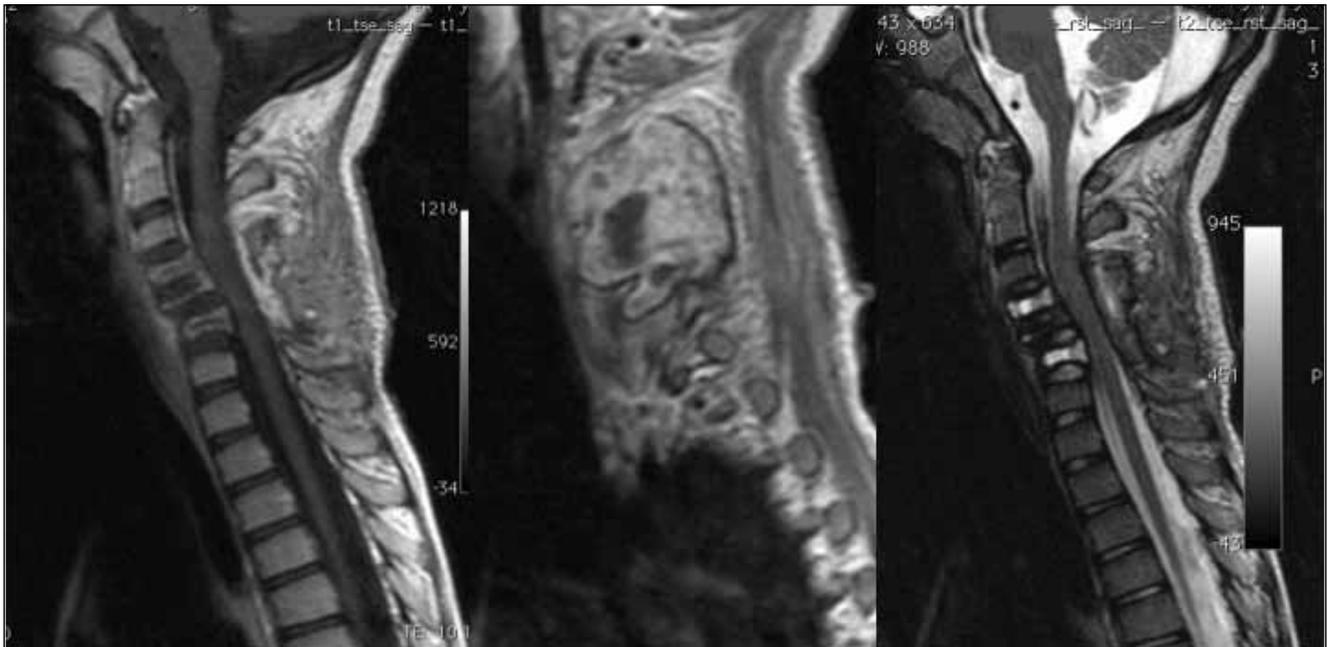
Preoperative T1 and T2 sagittal MRI disclosed secondary spinal stenosis and posterior and lateral enlargement of the bony lesion. They also show abnormal alignment of the vertebrae and collapse of C5.
